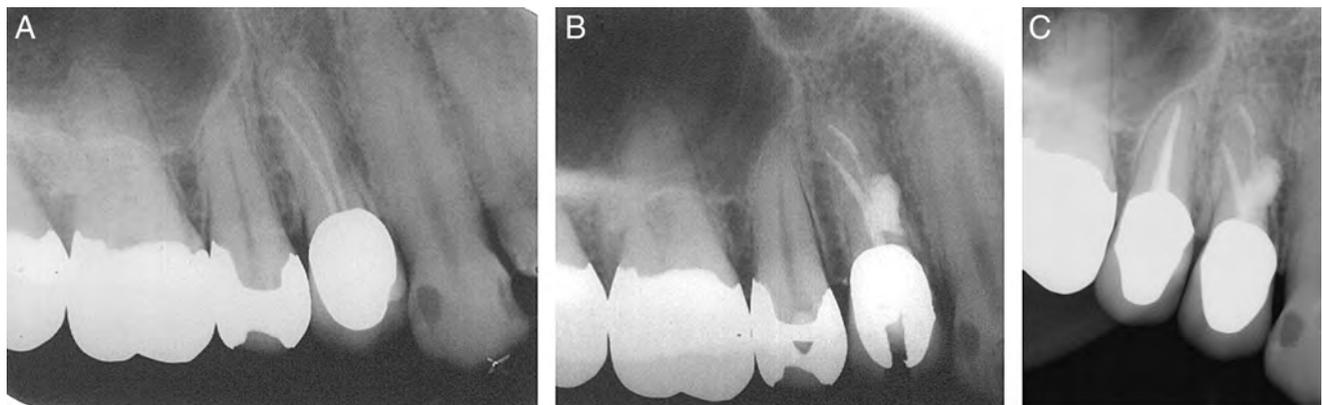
Case 4. (A) A preoperative radiograph of tooth #5. (B) After disassembly, a large lateral midroot perforation was visualized. A postoperative radiograph showing the perforation sealed with MTA and the root canal system retreated and obturated with warm gutta-percha. (C) A radiograph taken 5 years after perforation repair. The tooth was asymptomatic, functional, and restored with a PFM crown.
